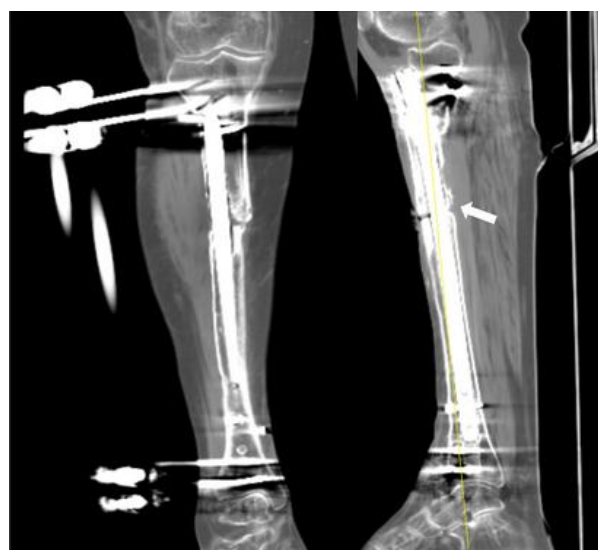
CT-Scan 20 Weeks After Second Surgery. Delayed Union (White Arrow).
